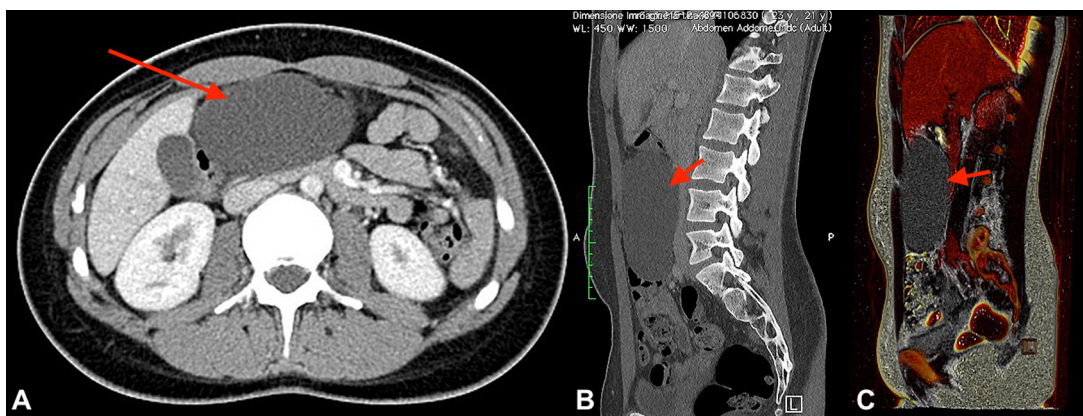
(a–c) CT scan show a large cyst located between the gallbladder, liver, aorta, vena cava, transverse colon, and some bowel loops.
